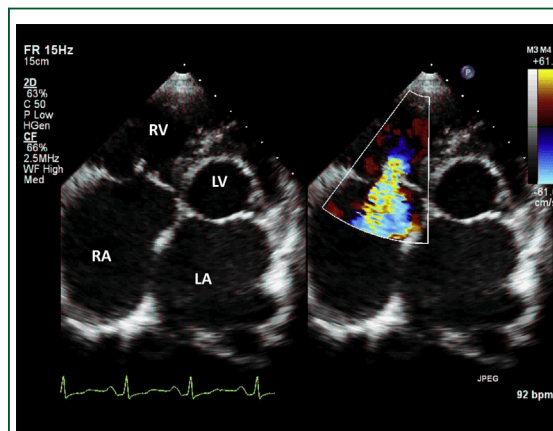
Apical 4-chamber view showing tricuspid regurgitation in a patient with rheumatic tricuspid stenosis. Abbreviations as in Figures 1 and 2.
